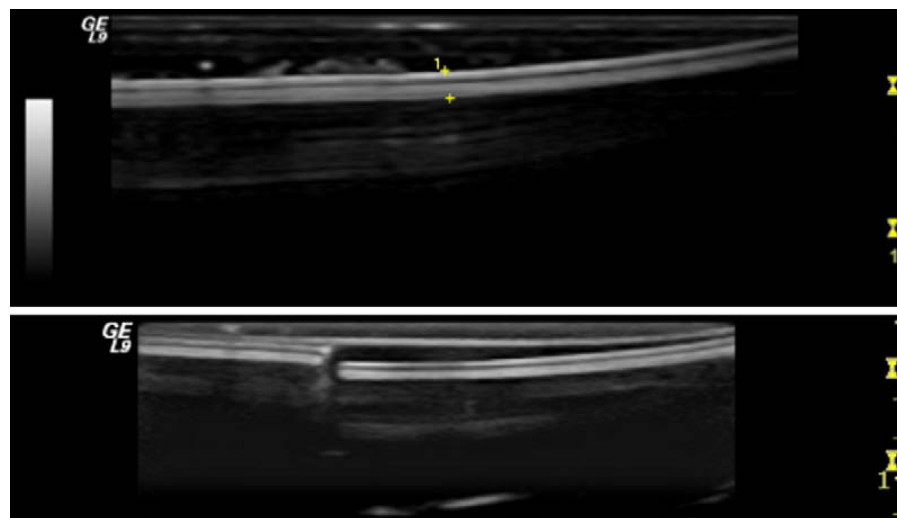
New high-resolution ultrasound images of an intact and cut “ruptured” smooth silicone Style 15 (Allergan) implant shell visualized with a GE LOGIQ-9 and M12Lprobe.
